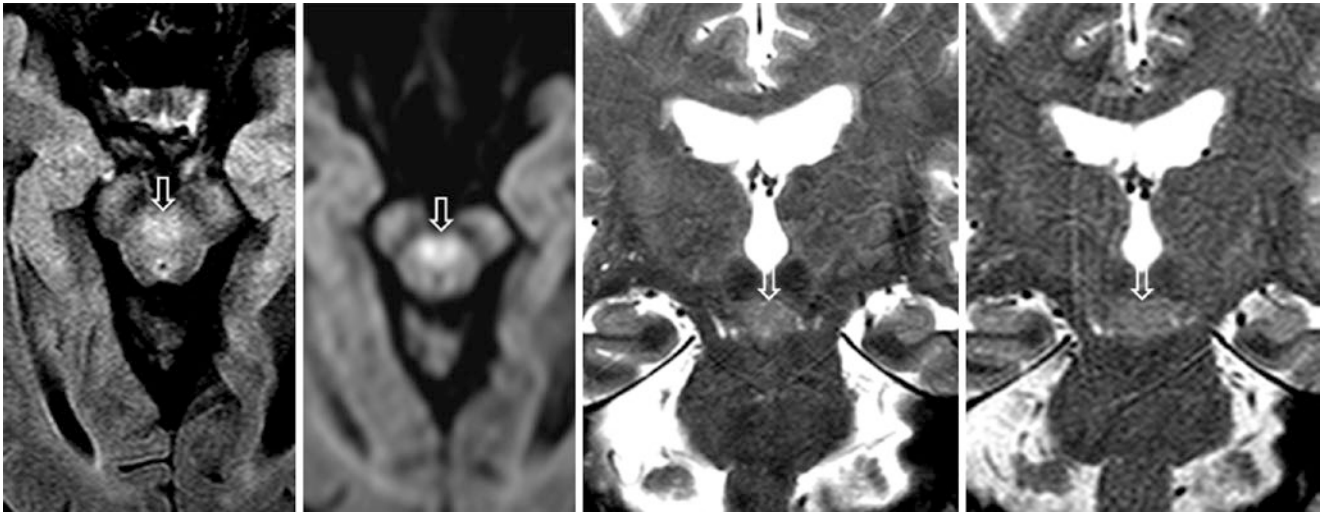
A 62-year-old had a 3 T MRI with axial FLAIR (*left*), DWI (*left middle*), and coronal T2WI (*right middle*), on which the decussation of the superior cerebellar peduncles (DSCP) (*open arrows*)
